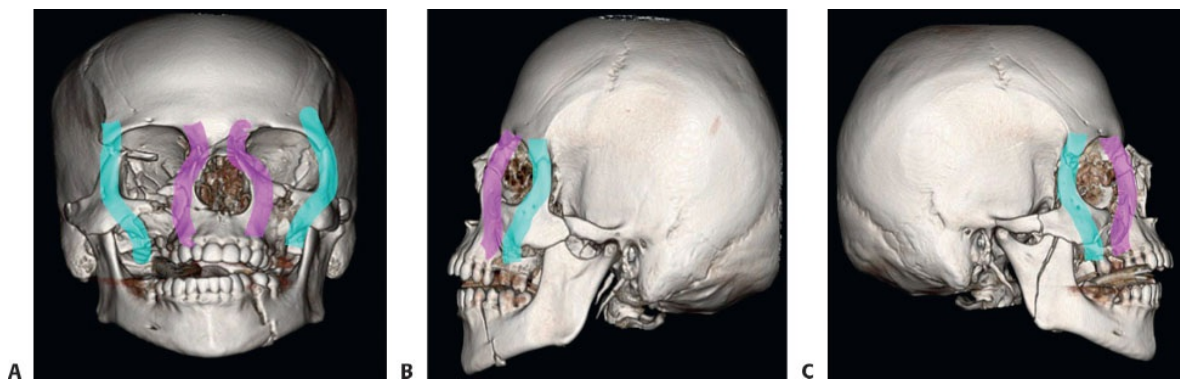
• 3D reconstructions created from CT maxillofacial coronal (A), axial (B), and sagittal (C) images of a 19-year-old healthy man with a Le Fort III
